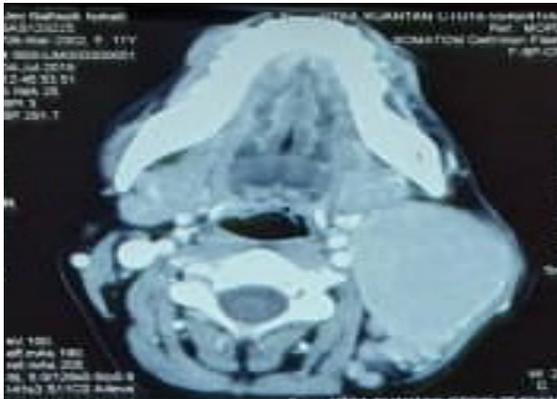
CT (axial) of the neck shows homogeneously enhancing left neck lesion compresses onto the adjacent right internal jugular vein
